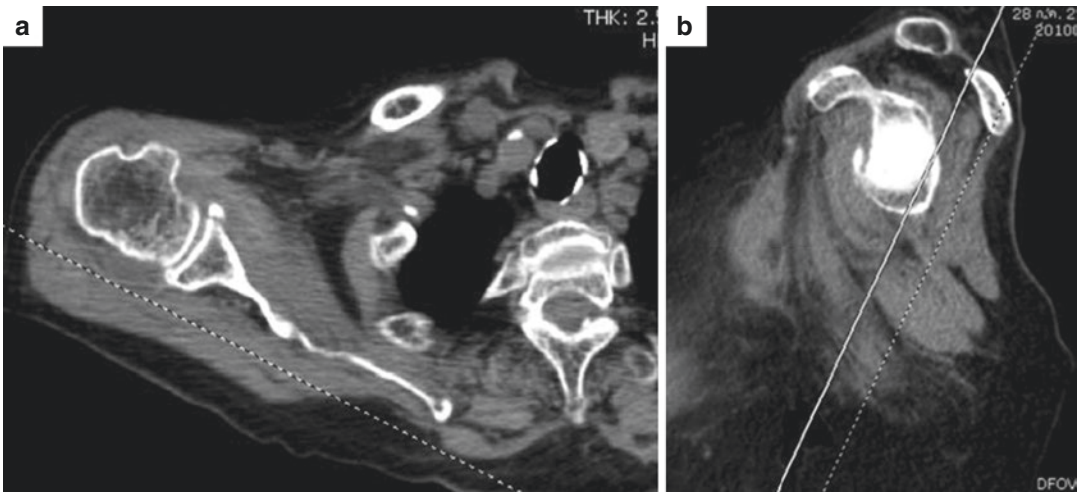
CT-2D (right shoulder) (a). Axial view (b). Sagittal view showing bone fragment at antero-inferior glenoid
